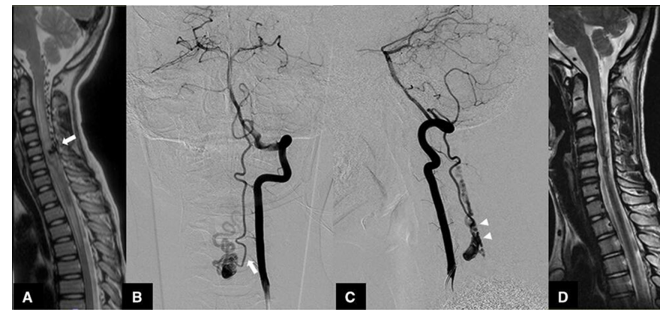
Example of perimedullary arteriovenous fistula (AVF) at the C5 spinal level. (a) Pretreatment sagittal T2-weighted magnetic resonance image (MRI) of the cervical spine shows a hyperintense T2 cord signal change from the craniocervical junction to the T4 level with a venous pouch at the C5 level (white arrow). (b) Anterior-posterior view of left vertebral artery injection shows an AVF that is fed by the left lateral spinal artery (white arrow). (c) Lateral view of the left vertebral artery injection shows an AVF draining into the posterior perimedullary vein (white arrowhead). (d) Posttreatment sagittal T2-weighted MRI of the cervical spine shows resolution of the hyperintense T2 cord signal change with hemosiderin deposition along the spinal cord at C2 to the T4 levels.
